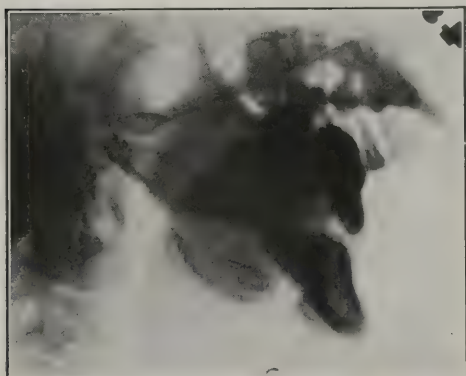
Case 6: Radiograph showing loss of substance in right body of mandible and collapse of symphysis.
